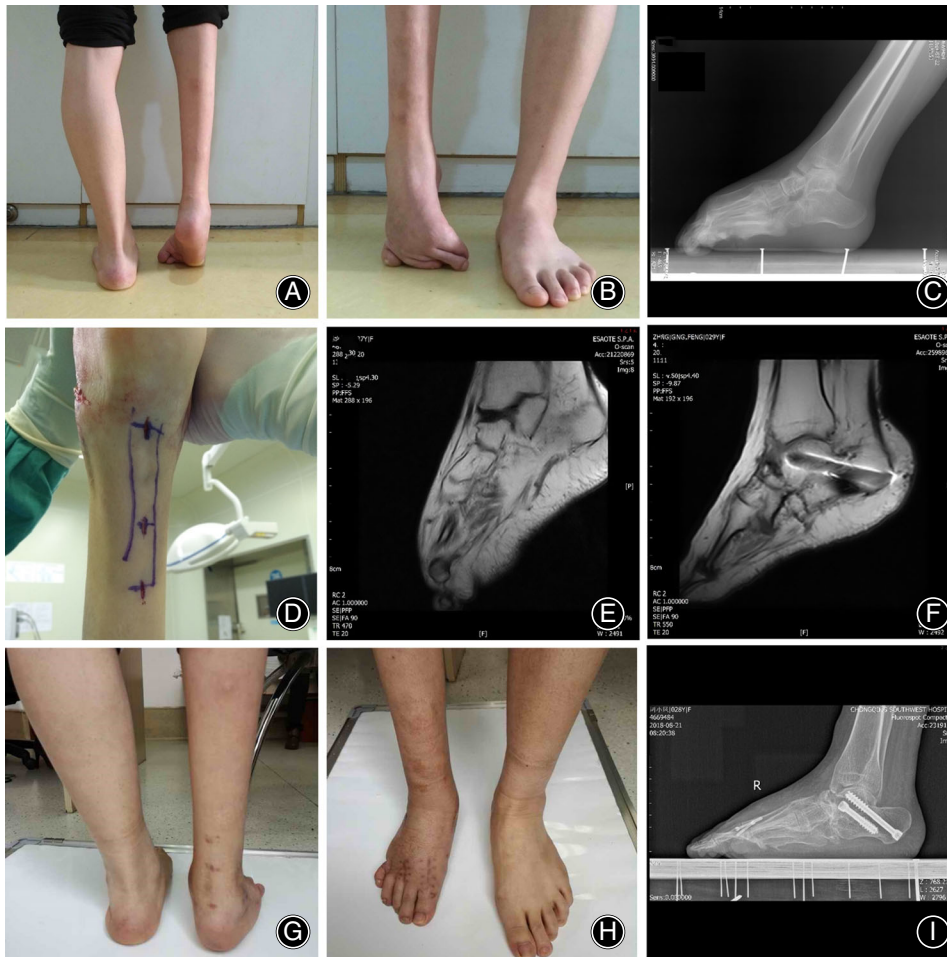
Typical Case 2: (A, B) general observation of the congenital deformity of the right ankle joint before surgery; (C) lateral radiograph of right ankle joint before surgery; (D) incision of the percutaneous Achilles tendon lengthening; (E) ankle joint MRI examination showed that the Achilles tendon was continuous; (F) at 1 year postoperatively, the re-examination of ankle joint MRI showed that the Achilles tendon was continuous, and the diameter was thicker than before surgery; (G, H) general observation of the right ankle joint at 6 months postoperatively, showing obvious improvement compared with before surgery and the plantigrade foot being restored; (I) lateral radiograph of right ankle joint at 6 months postoperatively.
